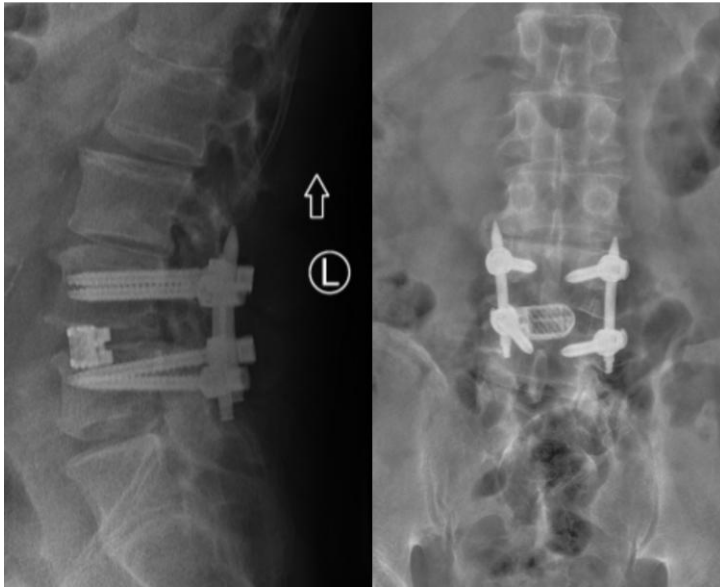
MIS-TLIF postoperative anteroposterior and lateral radiographs
